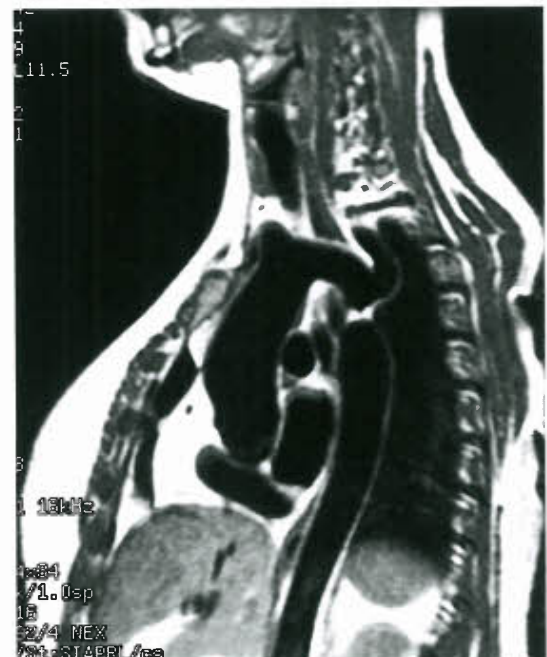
Magnetic resonance image in a sagittal projection demonstrating a discrete coarctation of the aorta just distal to the left subclavian artery. There is mild dilation of the descending aorta.
